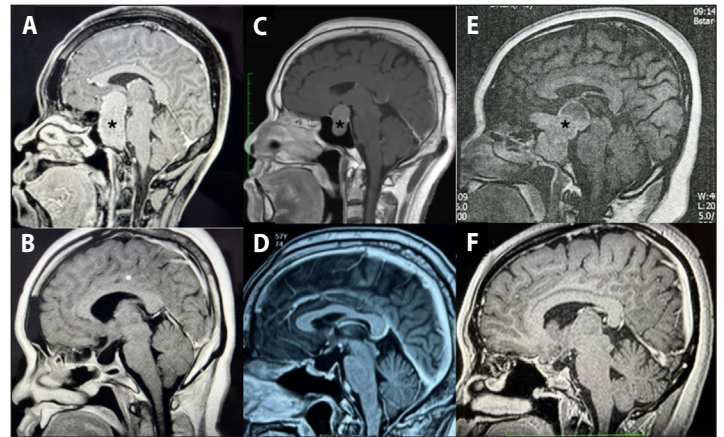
Representative cases, all tumors are marked with an asterisk A. preoperative MRI of a 39F with severe vision loss (light perception only) showing a 6cm pituitary tumor; B. her postoperative MRI showing gross total resection. Her visual acuity recovered to 20/100, but her hemianopsia did not improve; C. preoperative MRI of a 57M with vision loss (20/100 bilaterally) showing a 2.5cm pituitary tumor; D. his postoperative MRI showing gross total resection; his vision recovered completely; E. preoperative MRI of a 40F with severe vision loss (no light perception in the right eye, counting fingers in the left) showing a 5cm lobulated pituitary tumor; and F. her postoperative MRI showing gross total resection. Unfortunately, there was no improvement in vision after surgery.
